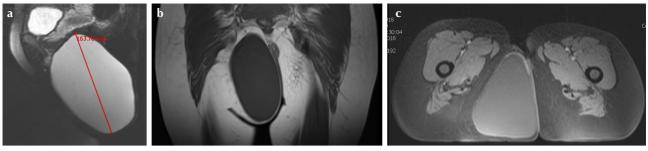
a-c. MRI sagittal T2-weighted images demonstrating a well-defined hyperintense lesion (a). MRI axial T1-weighted images showing a hypointense lesion without communication with the surrounding tissues (b). MRI frontal T2-weighted images demonstrating a well-defined hyperintense lesion (c).
